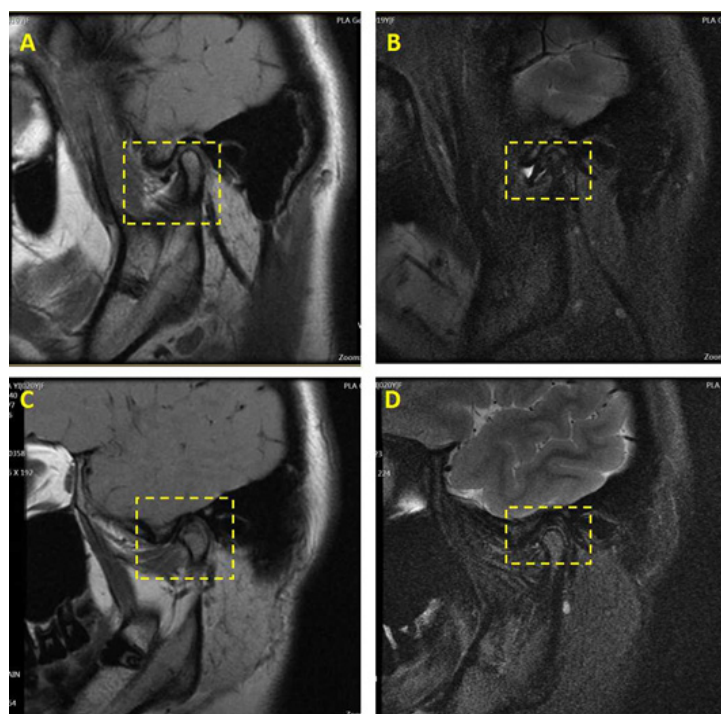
The MRI image of right TMJ. A and B was the pre-treatment image. C and D was the post-treatment image. Compared with A and B ,C and D showed reduced disc-condylar angle and disc-condylar distance effectively, no joint effusion after treatment.
